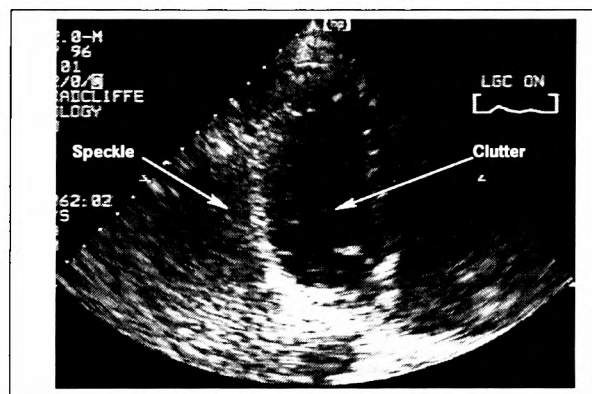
Noise in echocardiographic images. The noise in an echocardiographic image arises from two sources: spurious clutter inside the ventricle and speckle noise. This data was recorded on VHS video and then digitised.
